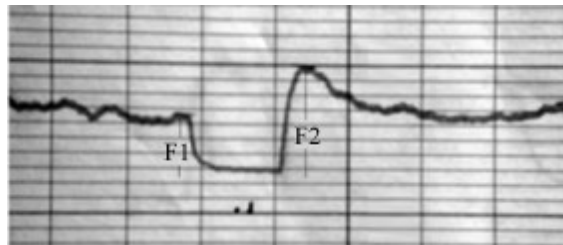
Example response from transient hyperaemic response test (THRT), measured from transcranial Doppler ultrasound (TCD), adapted from (Webster and Mahajan, 2002).
